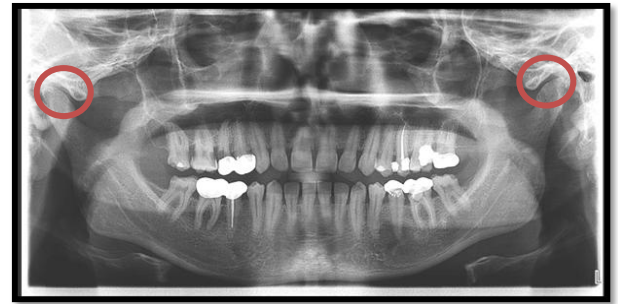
Panoramic radiograph showing bilateral and unilocular ZACD.
